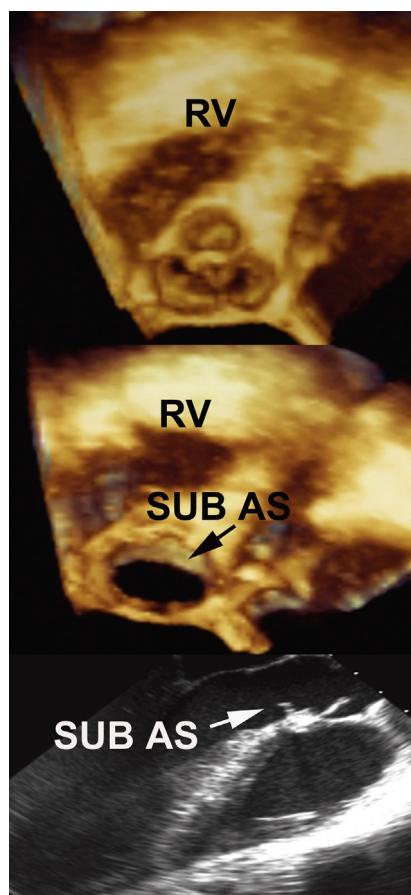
FIGURE e62-7 These images demonstrate fibromuscular subaortic stenosis as seen on three-dimensional echocardiography. The upper two panels show the aortic valve as seen by the surgeon, whereas the middle image is just distal to that and shows the crescent-shaped subaortic membrane. The lower image shows the fibromuscular ridge as seen on two-dimensional TEE. RV = right ventricle; SUB AS = subaortic stenosis.
